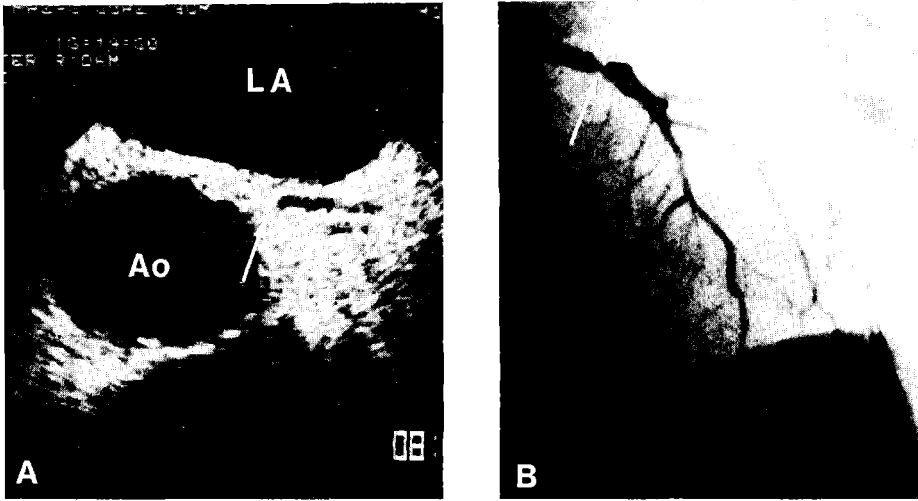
Transesophageal echocardiogram (A) and the corresponding coronary angiogram (B) showing a 90% stenosis of the left main coronary artery (arrow). Ao = aorta; LA = left atrium.
